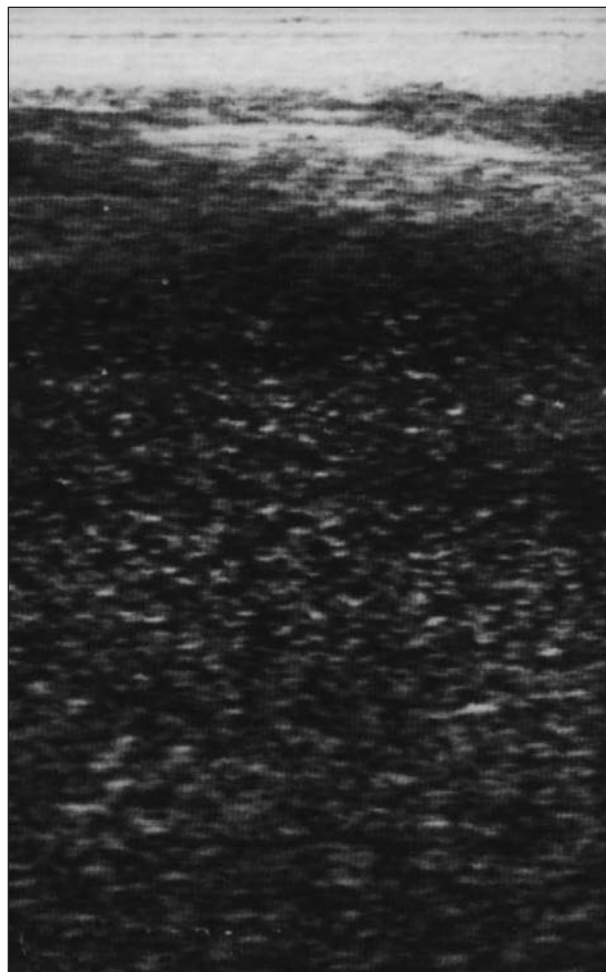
Ultrasonographic image of allantoic fluids in a pregnant mare on day 58 of gestation. Allantoic fluid score is 4. A dead fetus was identified by ultrasonography 48 hours later.
